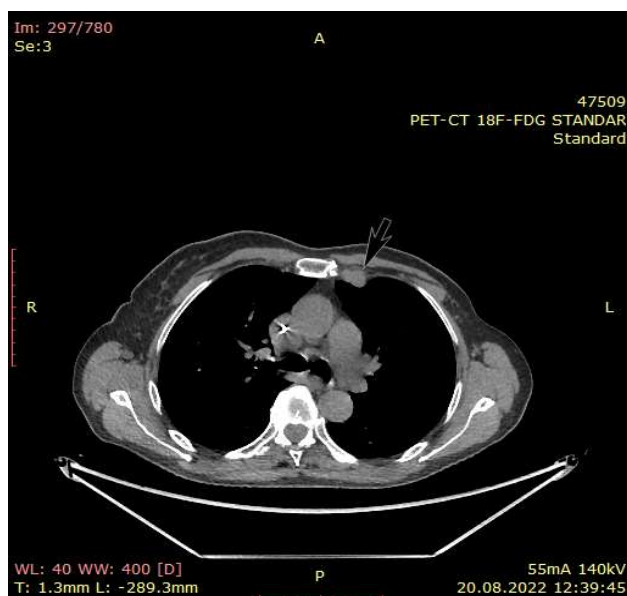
Metabolically active left parasternal lymph node (black arrow) - consistent with breast cancer recurrence, as seen in the PET-CT scan dated 20 August 2022.
